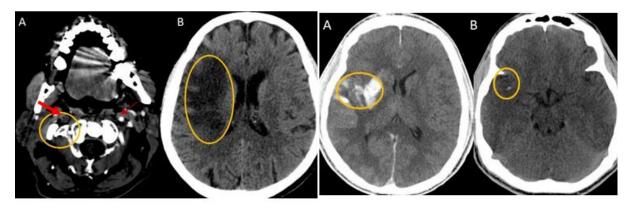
Stroke caused by plaque occlusion Figure 135. Head CT scan in a patient with of the right common carotid artery (A), Native CT scan that highlights the affected brain territory (B) (from Cuciureanu et al., 2019a)
